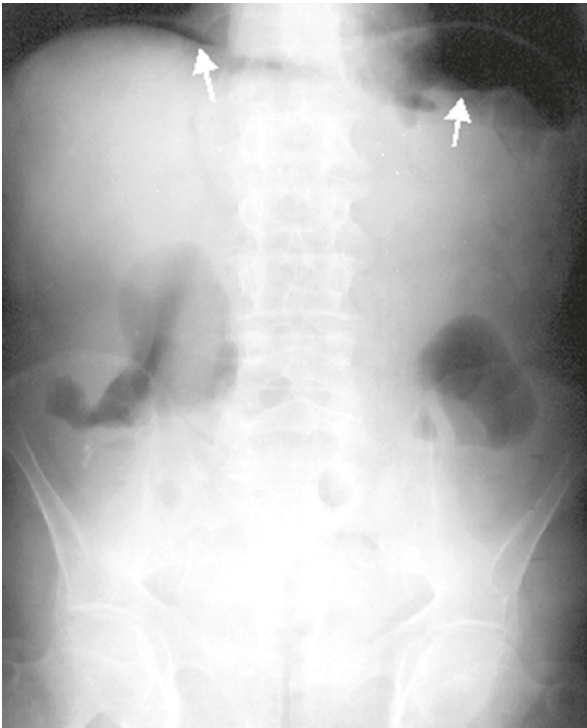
Abdominal X-ray, upright position. Pneumoperitoneum. Air under both diaphragms (arrows)
